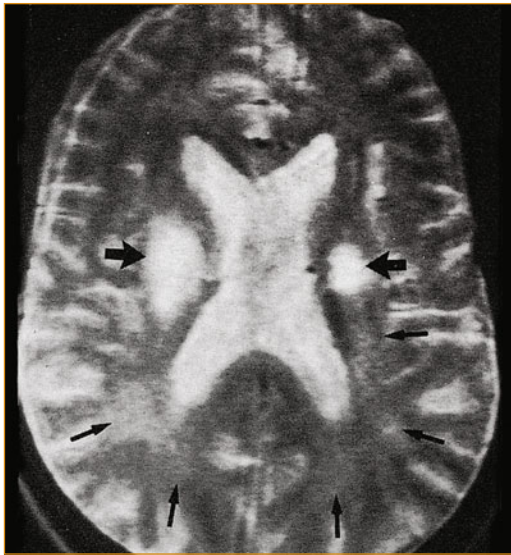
T2-weighted MRI scan showing bilateral diffuse (*small arrows*) and patchy white matter lesions (*large arrows*) in the brain of an AIDS patient. CT scans of HIV encephalopathy are nonspecific and only reveal diffuse atrophy with diffuse cortical atrophy and enlarged ventricles. T1-weighted MRI scans will also reveal diffuse atrophy. On T2-weighted MRI scans, in addition to atrophy, increased signal in the white matter is seen in 25% to 30% of AIDS patients. These changes may be diffuse or may be focal, patchy, or punctate. (From Olsen *et al.* [65], with permission.)
